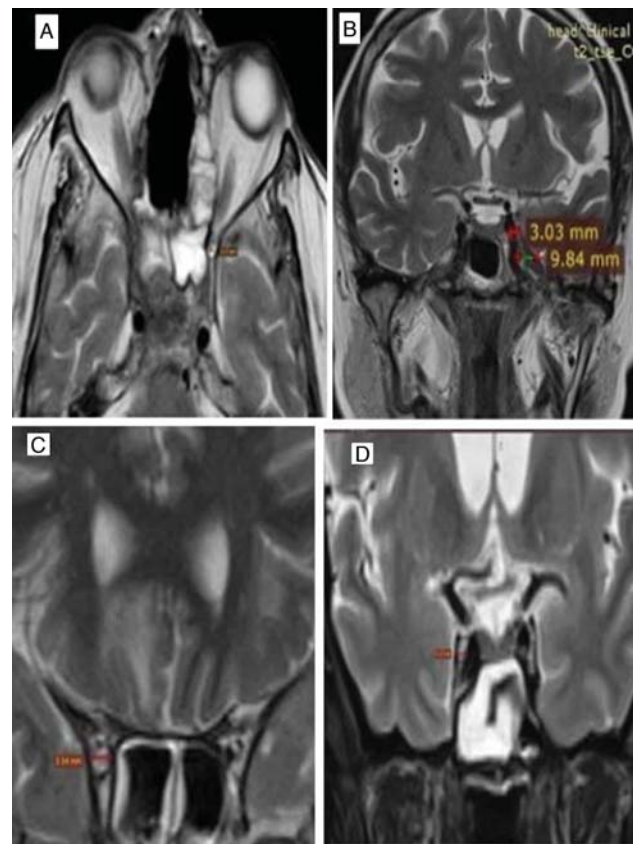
MRI, (A) axial projection. Occlusion / thrombus at the level of the superior ophthalmic vein. (B) coronal projection. There is an enlargement of the size of the cavernous sinus on the left. (C, D) coronal projection. Incomplete occlusion of the internal carotid artery in the cavernous sinus, there is hyperplasia of the mucous membrane of the right sphenoid sinus. MRI, magnetic resonance imaging.
